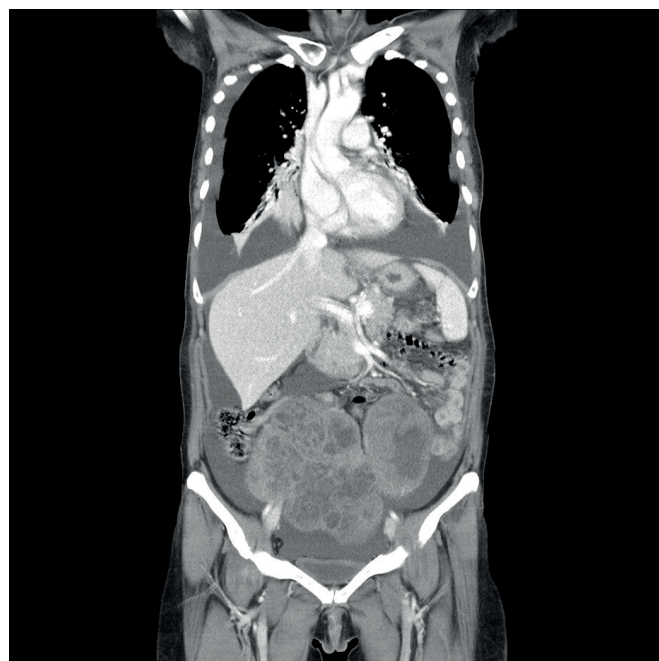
Coronal plane of abdominopelvic and chest computed tomography (CT) disclosed a huge multilobulated pelvic mass. Ascites and bilateral pleural effusions were present.
